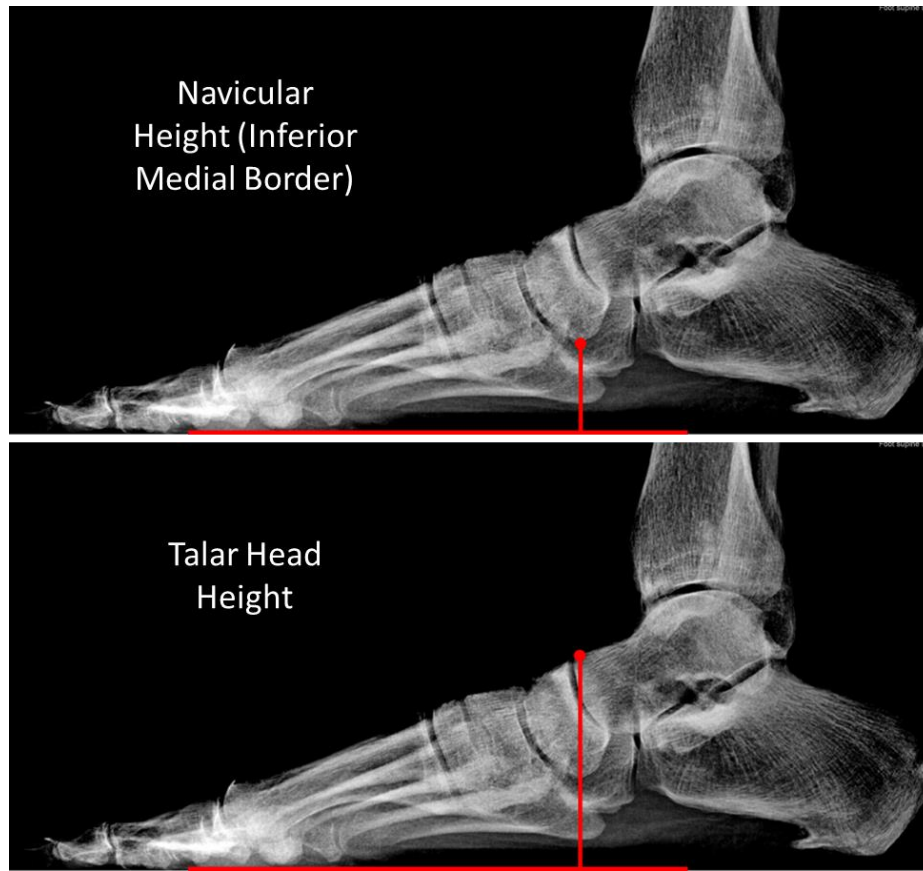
Radiographic Measurements
